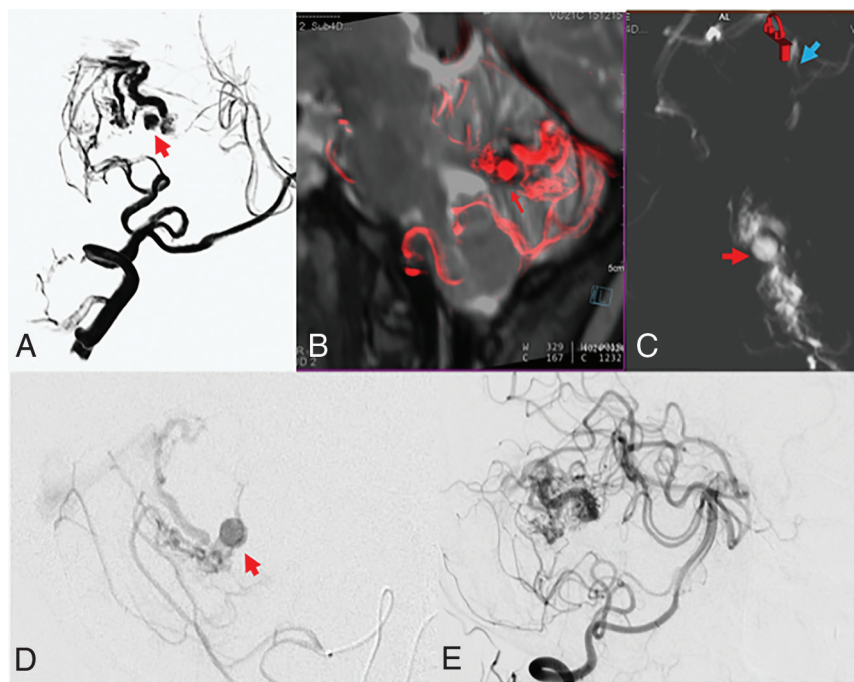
Posterior fossa AVM in an 18-year-old woman with cerebellar hemorrhage. A and B, Virtual DSA and sagittal reconstructions of fused images between MR imaging and 4D fPCBCTA show an intranidal aneurysm (red arrows). C, Axial MPRs demonstrate the origin of the aneurysms from the branches of the small nidus just proximal to the transition into the draining vein (blue arrow). D, Corresponding findings by superselective angiography. E, Occlusion of the aneurysm after targeted embolization. Note the diffuse nidus with a low degree of branching and dominance of single microfistulous channels.
